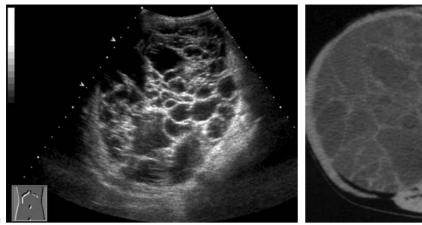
Cystic partially differentiated nephroblastoma (*CPDN*) in an 8-month-old boy. Both US (a) and enhanced CT scan (b) show a well-limited, purely cystic mass with multiple septations
